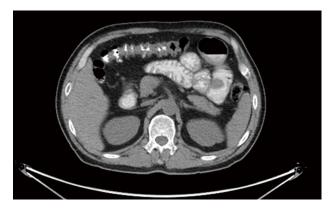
positron emission tomography/computed tomography showed a 36 mm × 33 mm intestinal mass with multiple peripheral lymph nodes in the right midabdomen.
